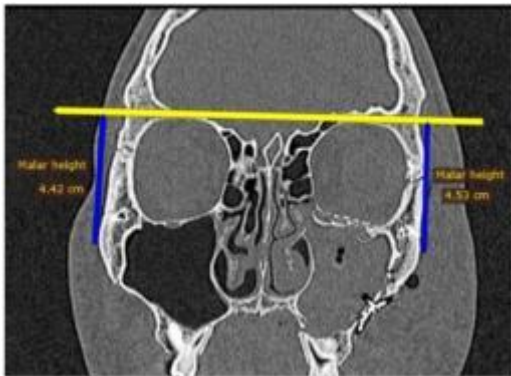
Postoperative radiographic malar height on both sides.
